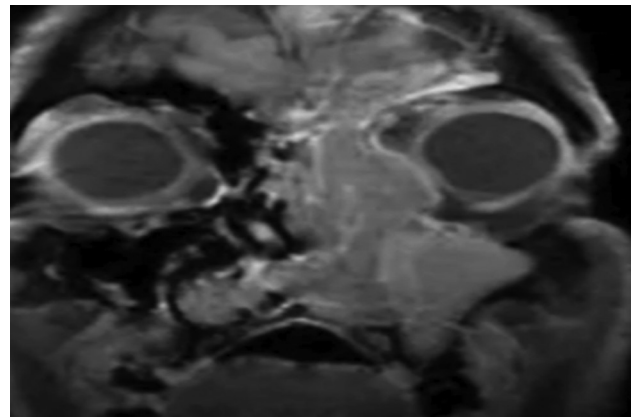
Pre-operative magnetic resonance imaging of the patient's nasal cavity
